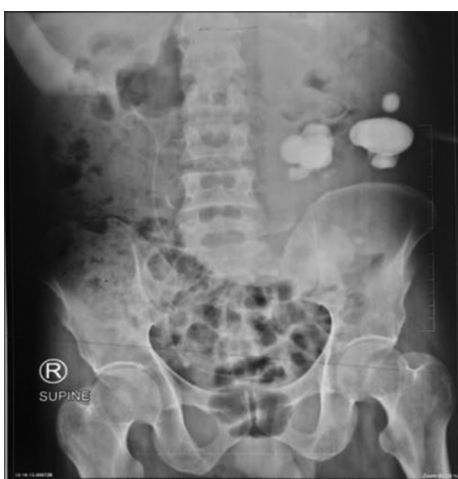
Plain abdominal radiograph showed large, multiple renal calculi
